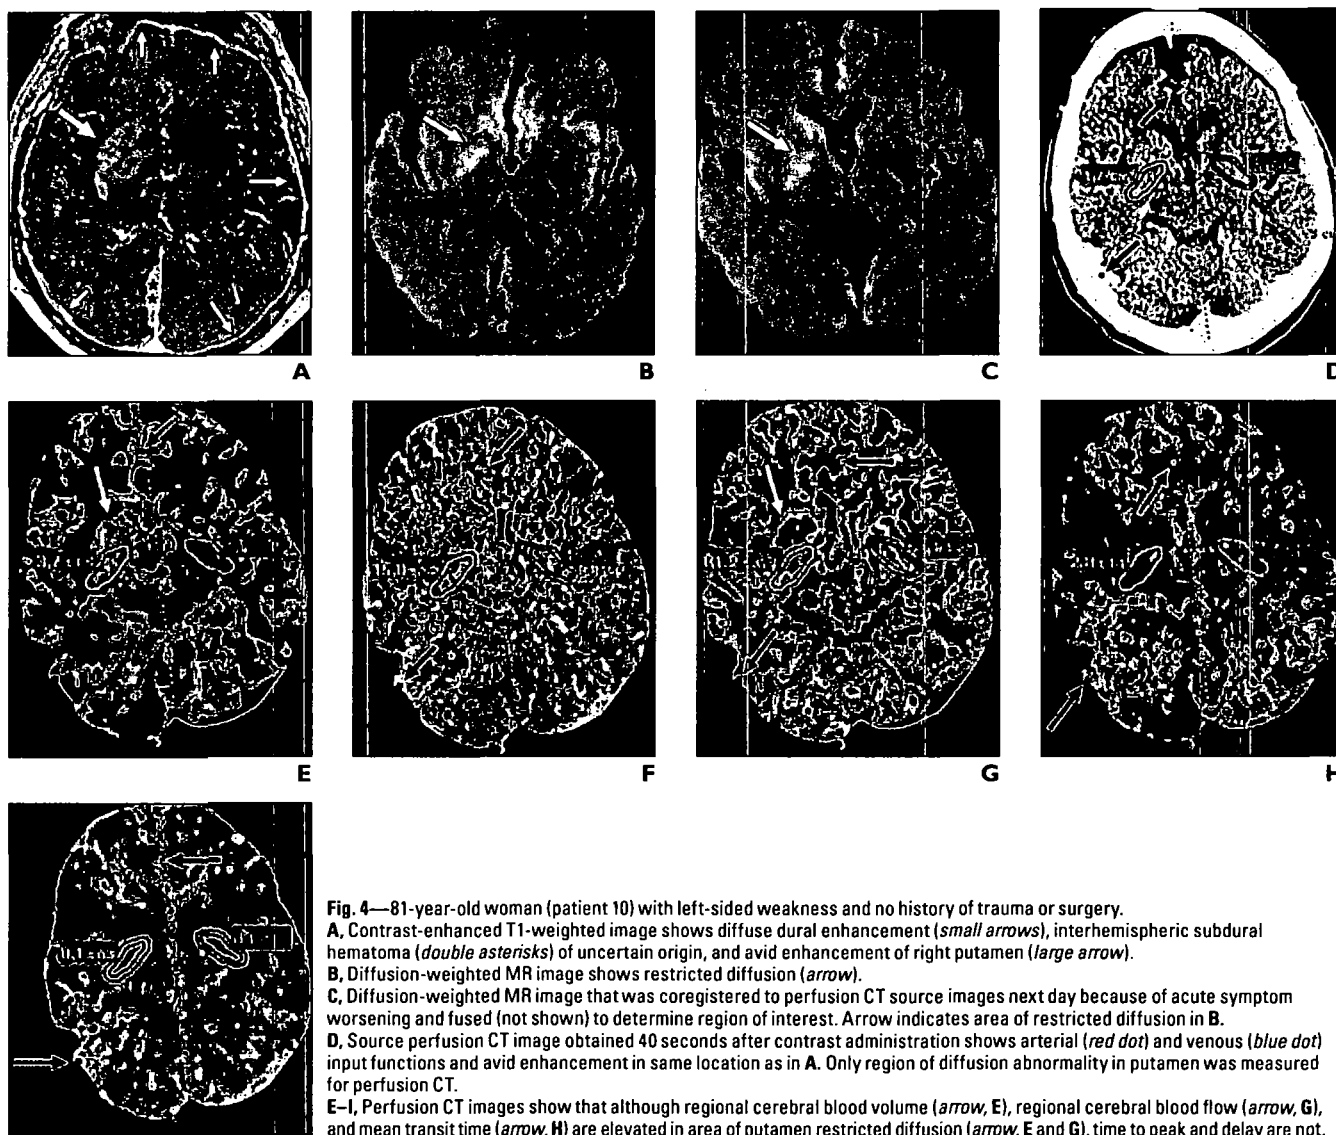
81-year-old woman (patient 10) with left-sided weakness and no history of trauma or surgery. A, Contrast-enhanced T1-weighted image shows diffuse dural enhancement (*small arrows*), interhemispheric subdural hematoma (*double asterisks*) of uncertain origin, and avid enhancement of right putamen (*large arrow*). B, Diffusion-weighted MR image shows restricted diffusion (*arrow*). C, Diffusion-weighted MR image that was coregistered to perfusion CT source images next day because of acute symptom worsening and fused (not shown) to determine region of interest. Arrow indicates area of restricted diffusion in B. D, Source perfusion CT image obtained 40 seconds after contrast administration shows arterial (*red dot*) and venous (*blue dot*) input functions and avid enhancement in same location as in A. Only region of diffusion abnormality in putamen was measured for perfusion CT. E–I, Perfusion CT images show that although regional cerebral blood volume (*arrow*, E), regional cerebral blood flow (*arrow*, G), and mean transit time (*arrow*, H) are elevated in area of putamen restricted diffusion (*arrow*, E and G), time to peak and delay are not.
